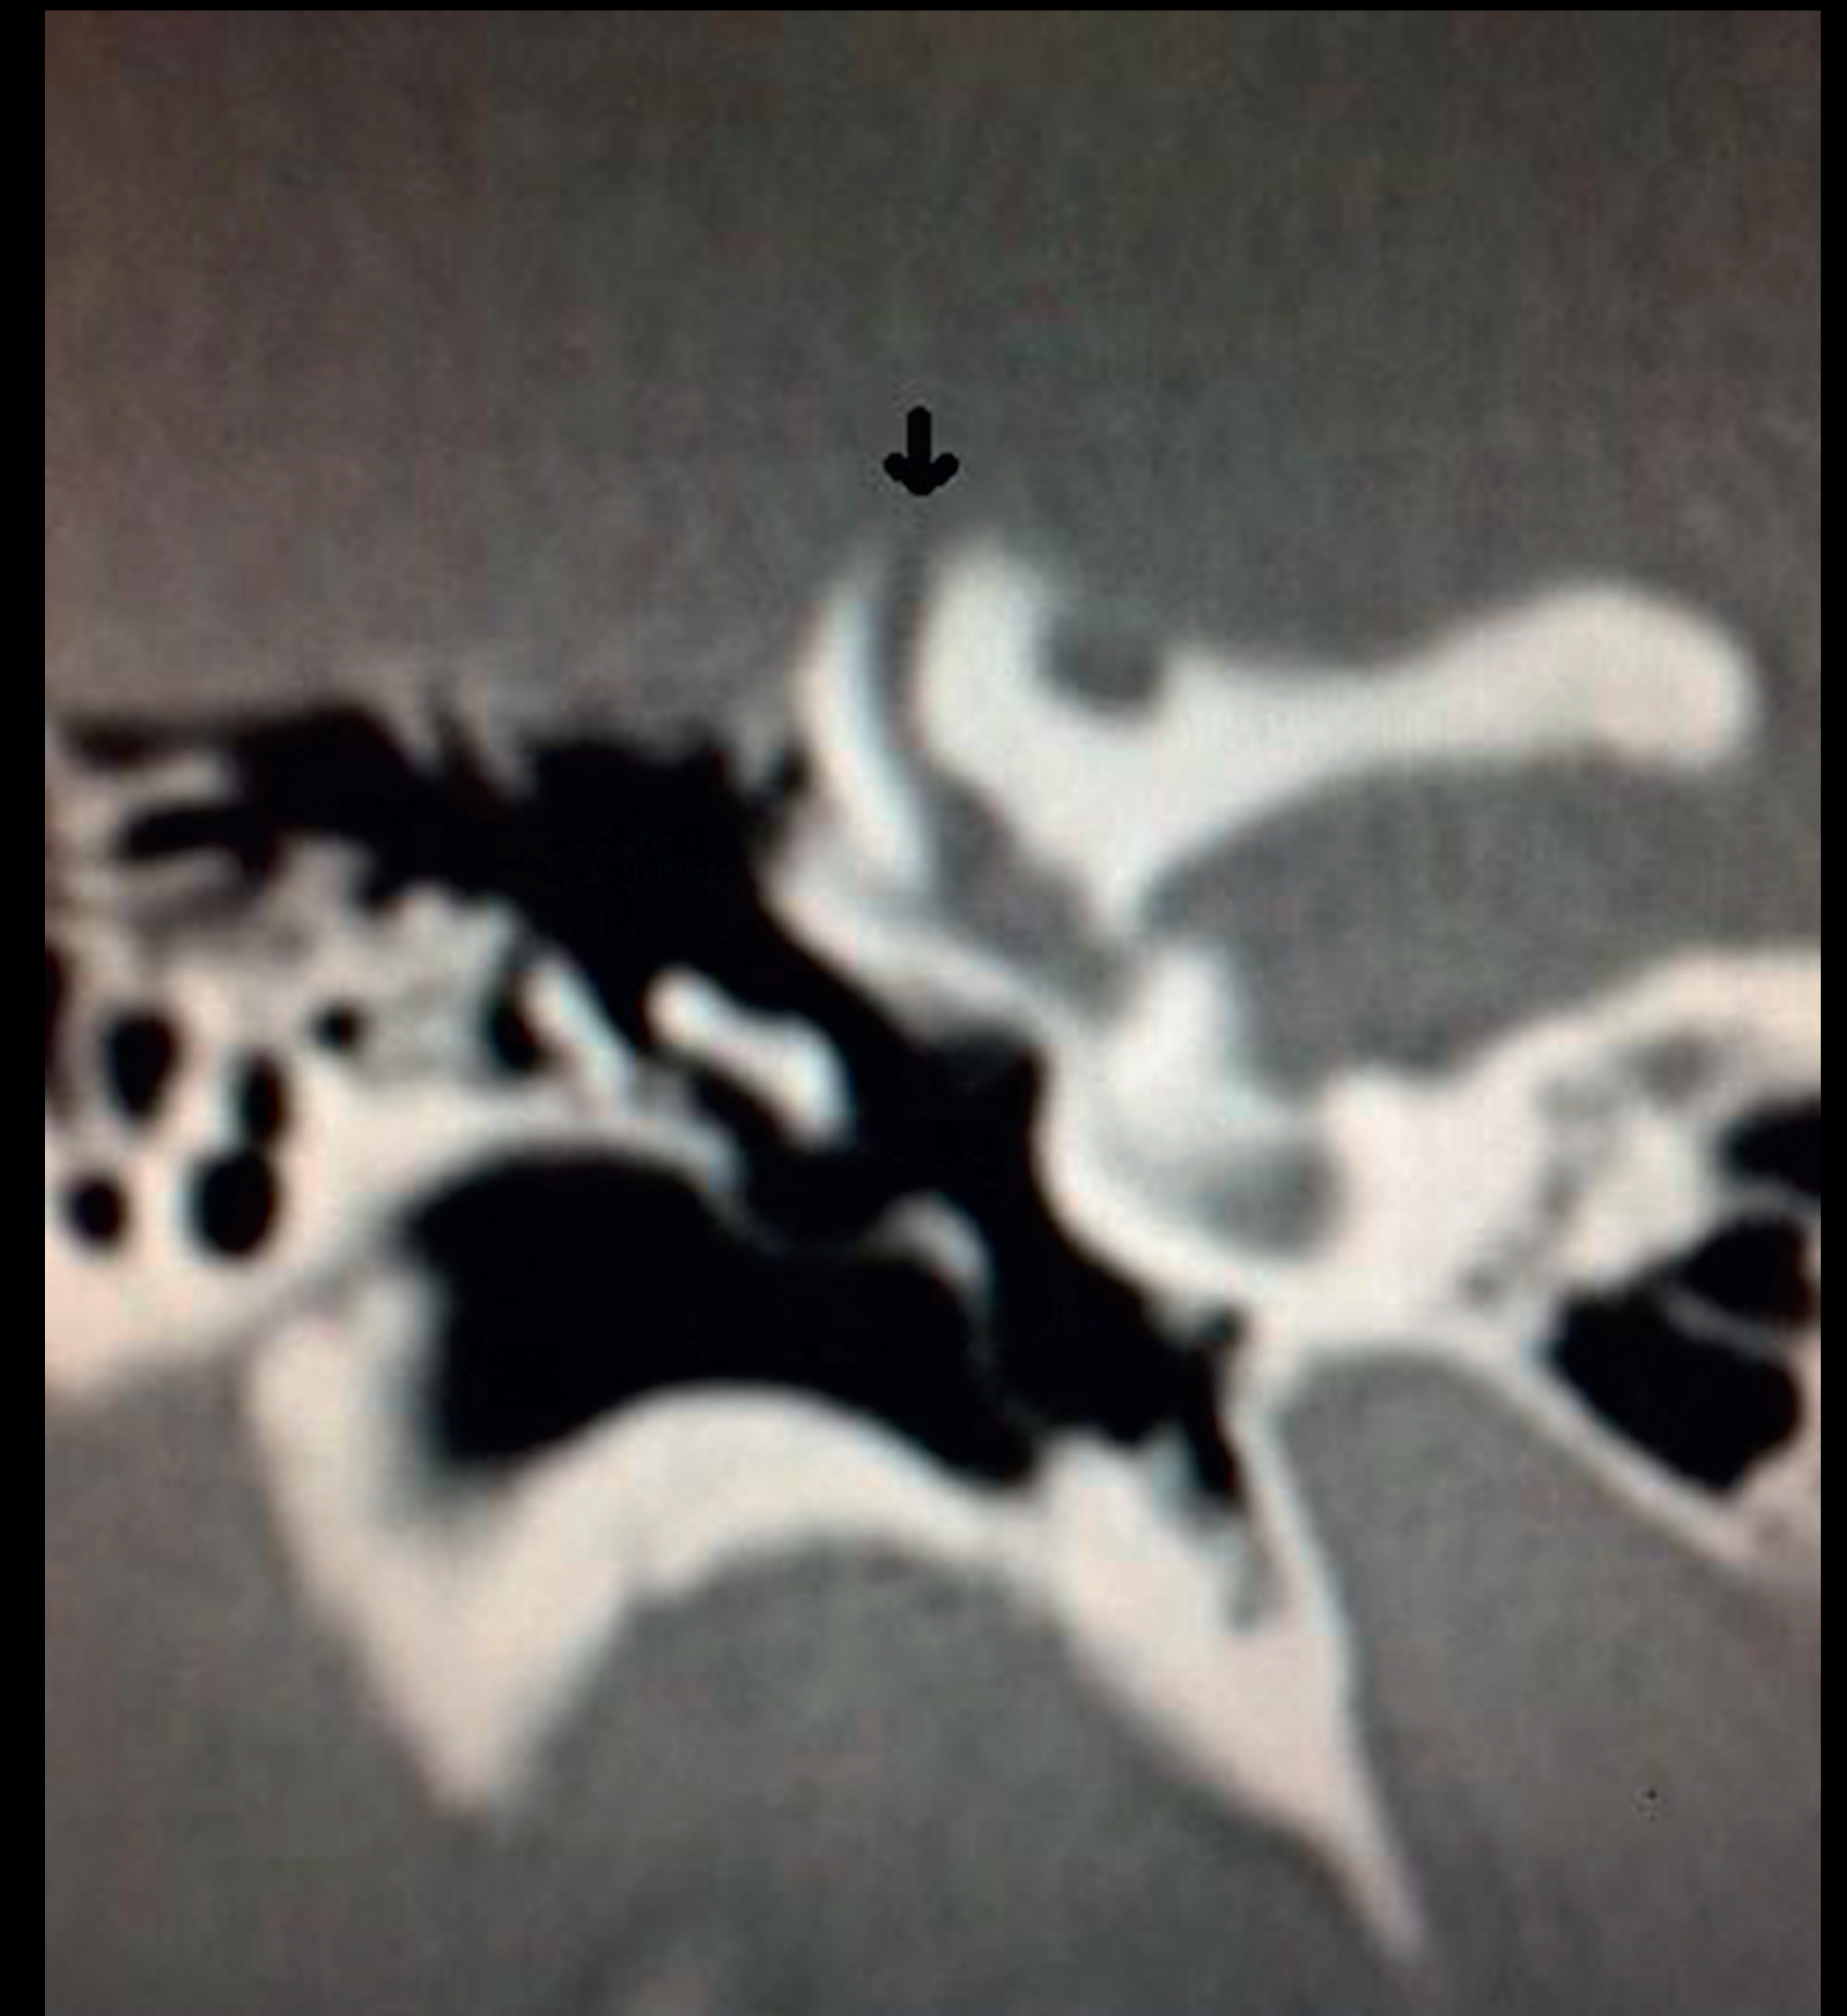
Preoperative Computed Tomography image of the right temporal bone. The arrow on the image shows the absence of bony coverage of the Superior Semicircular Canal.
